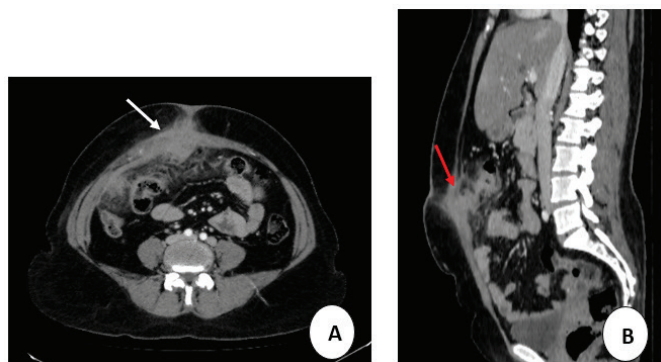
Contrast-enhanced CT Abdomen and pelvis (Axial and Sagittal views)
